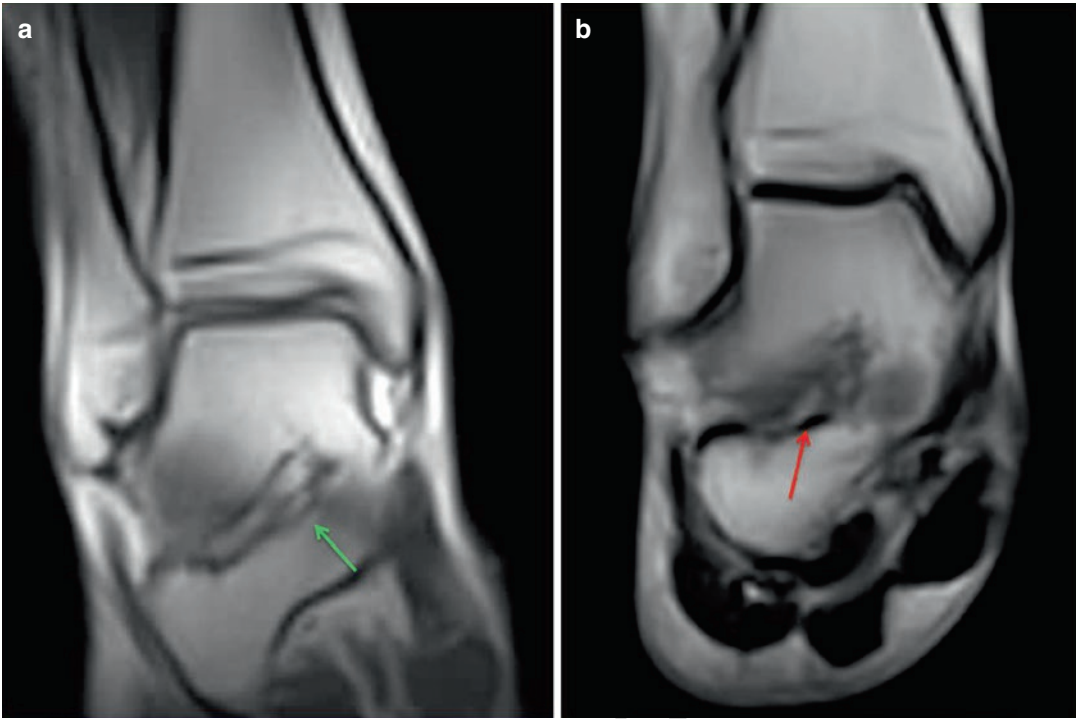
(a, b) Dynamic MRI acquired with the ankle rotated medially. Left, normal ligament; right, severe distraction of the interosseous ligament at the level of the tarsal sinus
